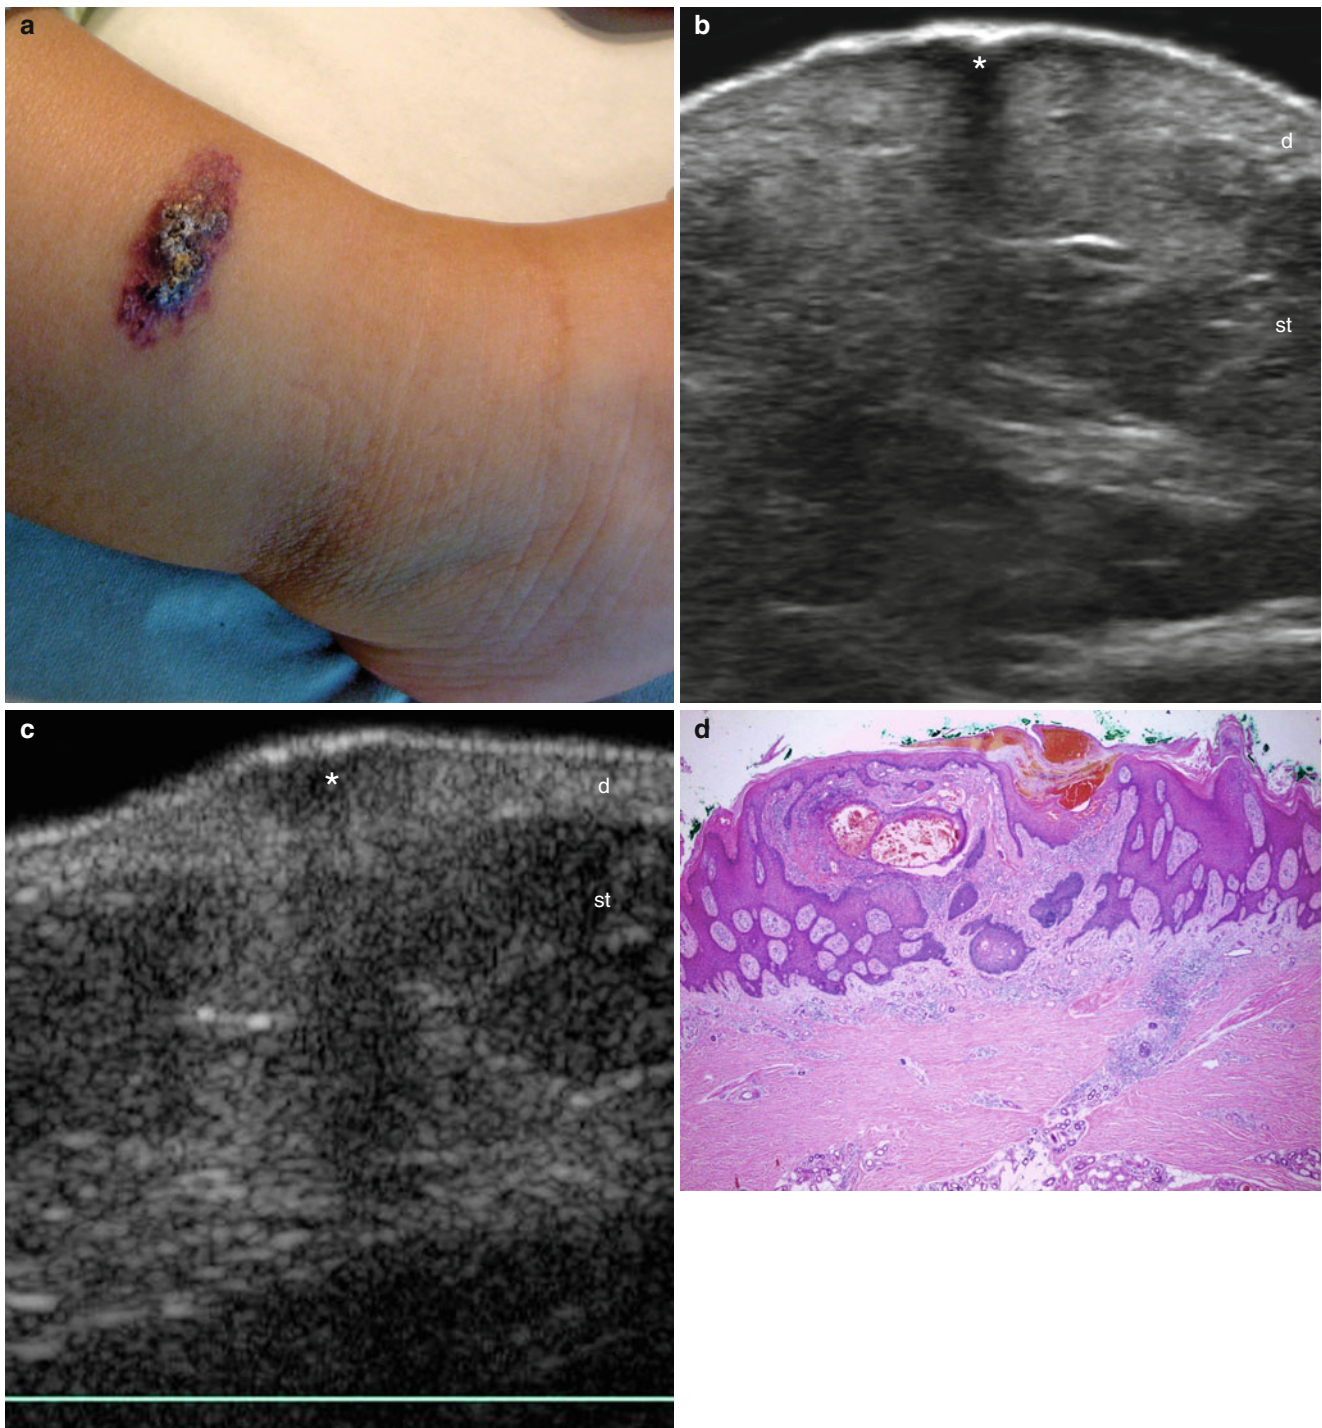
(a–d) Angiokeratoma. (a) Clinical reddish lesion in the anterior aspect of the right leg. (b) Grey scale ultrasound (transverse view) shows hypochoic region (*) in the dermis that generates a tiny posterior acoustic shadowing artifact. Notice the thickening of the epidermal
